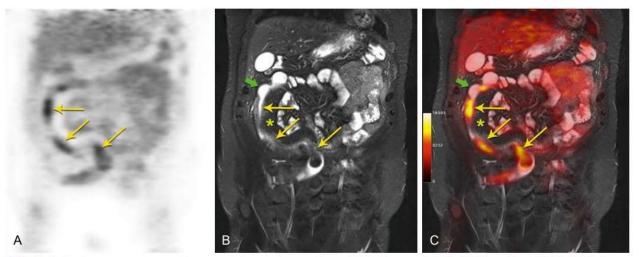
Crohn disease, coexistence of active and chronic changes. Coronal PET (A), coronal STIR MRI (B), and fused PET/MRI (C). Discontinuous areas of active inflammation (arrows) demonstrate increased focal FDG uptake, bowel wall thickening, and edema. Note adjacent fibrofatty proliferation (asterisk) and pseudosacculations indicative of the chronicity of the process. (From Furtado FS, Suarez-Weiss KE, Amorim BJ, et al. Gastrointestinal imaging. In Catalano A (ed). Clinical PET/MRI. London: Elsevier, 2023. Fig 14.15.)
